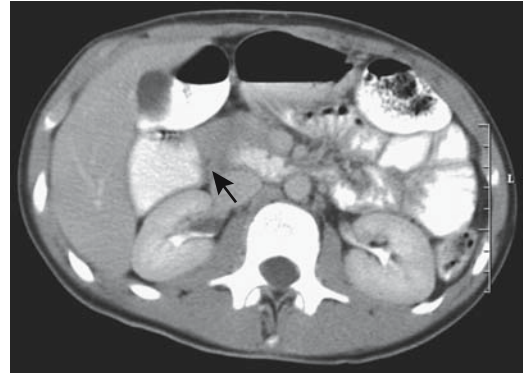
Severe superior mesenteric artery syndrome. Oral and intravenous contrast-enhanced CT reveals marked dilation of the descending duodenum and an abrupt cut-off in the third portion (arrow). The superior mesenteric artery and vein had a normal relationship. The patient underwent a duodenojejunostomy. (Courtesy of Patrick Fultz, M.D., University of Rochester.)
